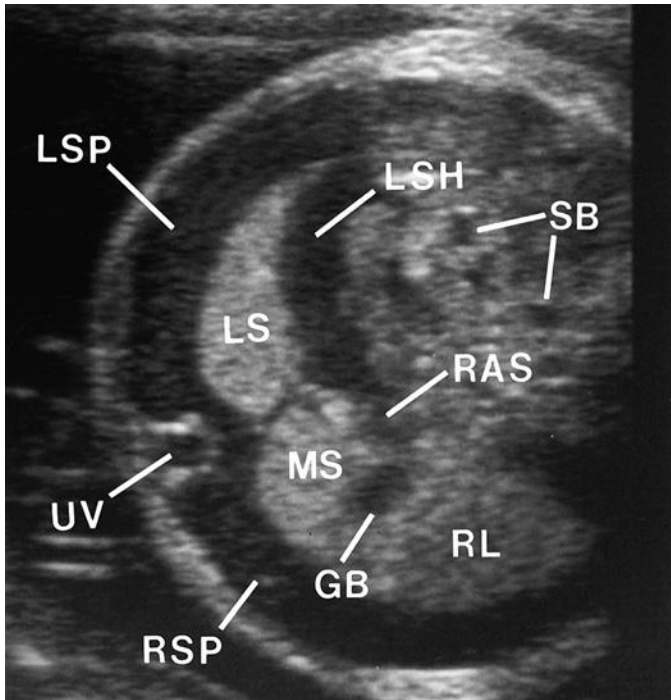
Transverse axial sonogram of the fetal abdomen after an intraperitoneal transfusion for Rh isoimmunization enables recognition of many peritoneal spaces, including the right (RSP) and left (LSP) subphrenic spaces and the right anterior (RAS) and left subhepatic (LSH) spaces. Segmental anatomy of the fetal liver is also well seen, including the medial (MS) and lateral (LS) segments of the left hepatic lobe. GB, gallbladder; RL, right hepatic lobe; SB, small bowel; UV, umbilical vein.
